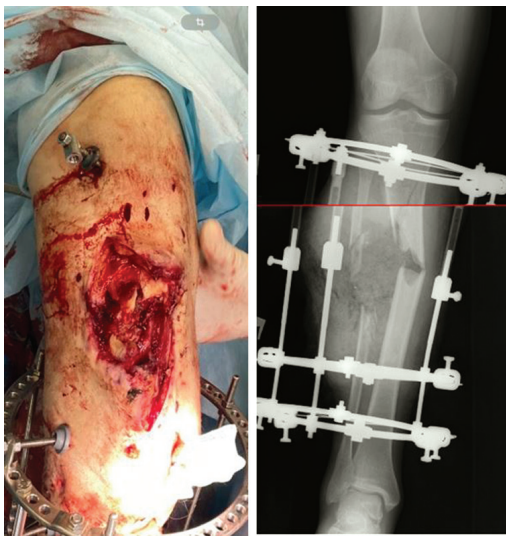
Photo and radiograph of the right tibia upon admission
